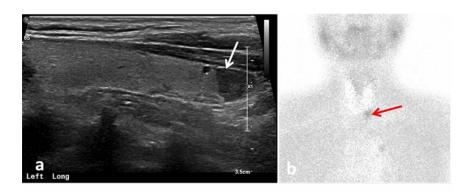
Longitudinal thyroid ultrasound image of a 61-year-old female (a) reveals a hypoechoic nodule inferior to the lower pole of the left thyroid lobe (white arrow). Thyroid scintigraphy scan (b) reveals a focus of increased sestamibi tracer uptake (red arrow) with delayed tracer washout projected over the lower pole of the left thyroid lobe, corresponds to the abnormality on thyroid ultrasound which is consistent with a parathyroid adenoma.
